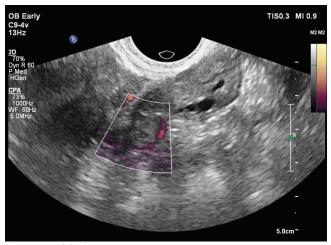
TVS power Doppler image showing peripheral vascularity in lesion.
